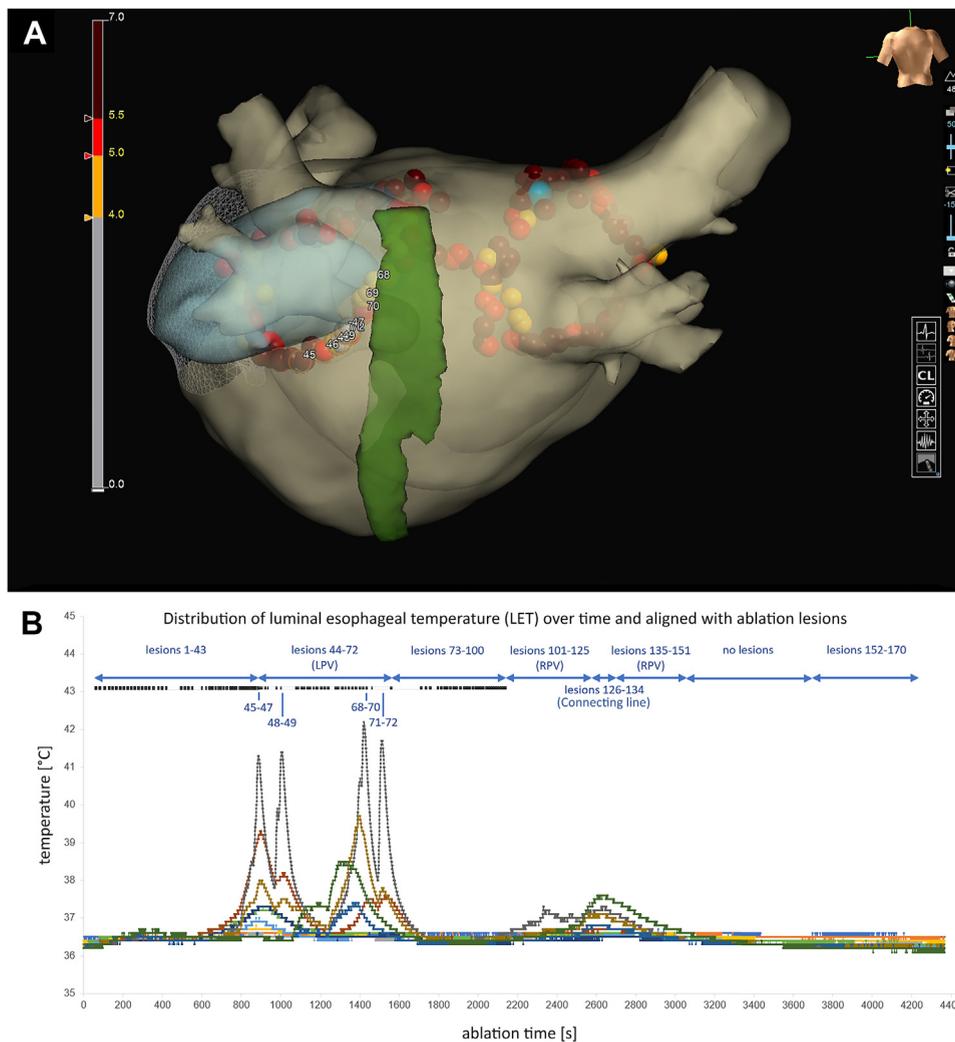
A: Three-dimensional reconstruction of the left atrium, esophagus, and pulmonary veins (Abbott EnSite Verismo; Abbott Inc, Chicago, IL). Ablation lesion set (yellow and red dots) with 2 wide antral lines encircling the pulmonary veins and an interconnecting posterior line. The left atrial appendage is displayed in blue color. Computed tomography-segmented esophageal course (green). The ablation lesions associated with the esophageal perforation site are displayed with the corresponding lesion numbers (45–49 and 68–72), the analysis of the lesion parameters is given in Supplemental Table 1. B: Luminal esophageal temperature (LET) curves of all 12 thermocouples showing 2 double peaks (maximum LET 42.2°C; Supplemental Table 1) corresponding to the ablation lesions 45–49 and 68–72. The connecting line (lesions 126–134) should have been performed with a larger distance to the esophageal course (at the left atrial roof rather than at the closest point between the 2 circles). However, analyzing the temperature data, this line was not associated with a suspicious LET rise (max. 37.6°C). The timing of the ablation lesions was integrated in the figure.
